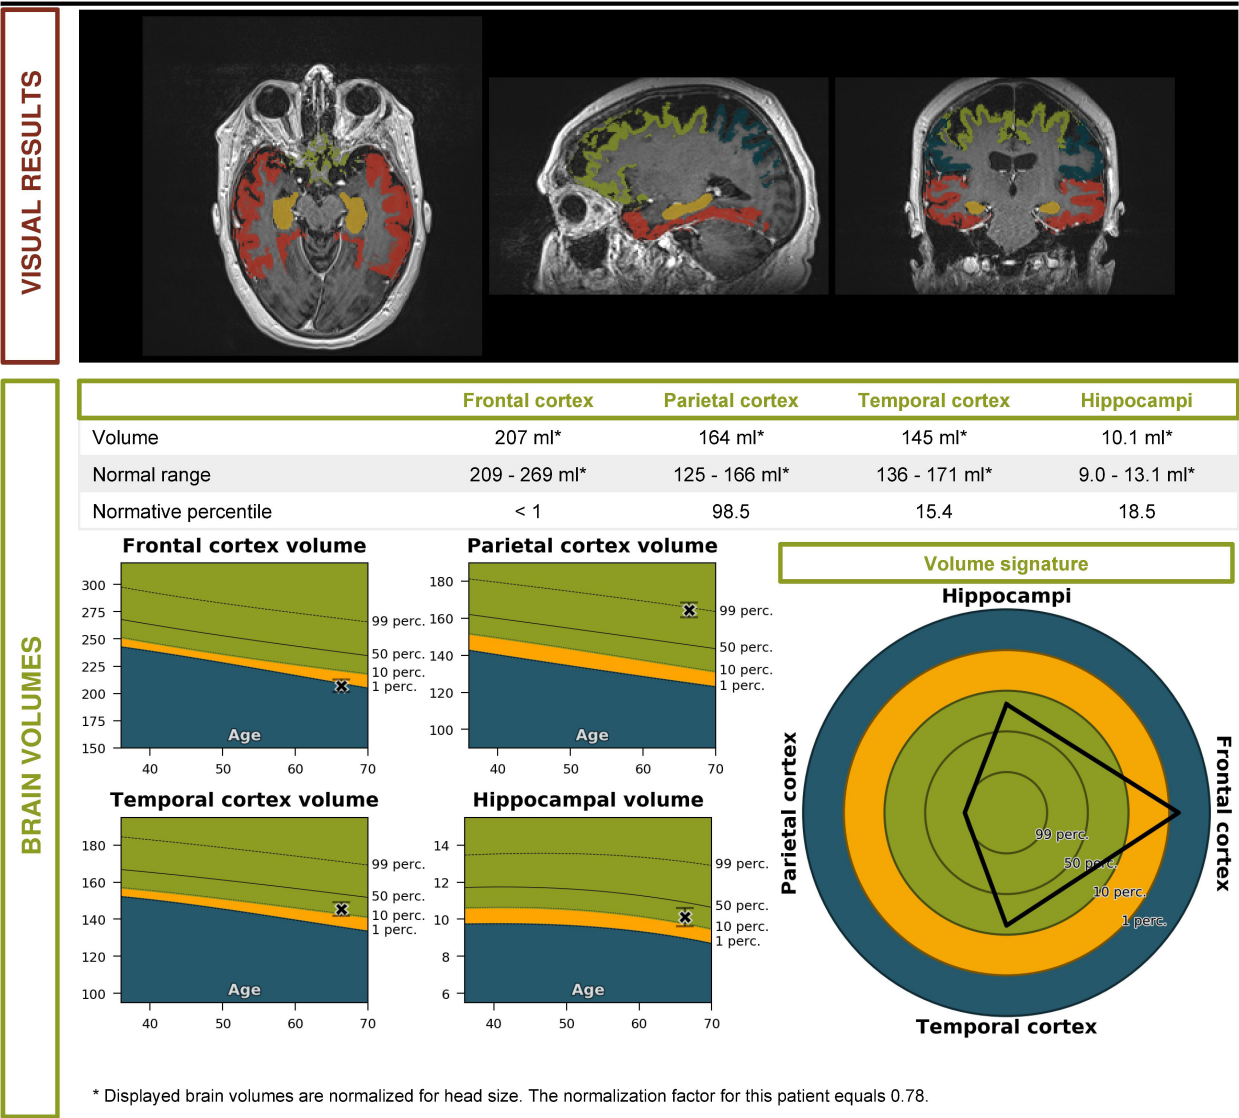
Volumetric brain MRI of the patient described in the clinical vignette (report by Icometrix).
